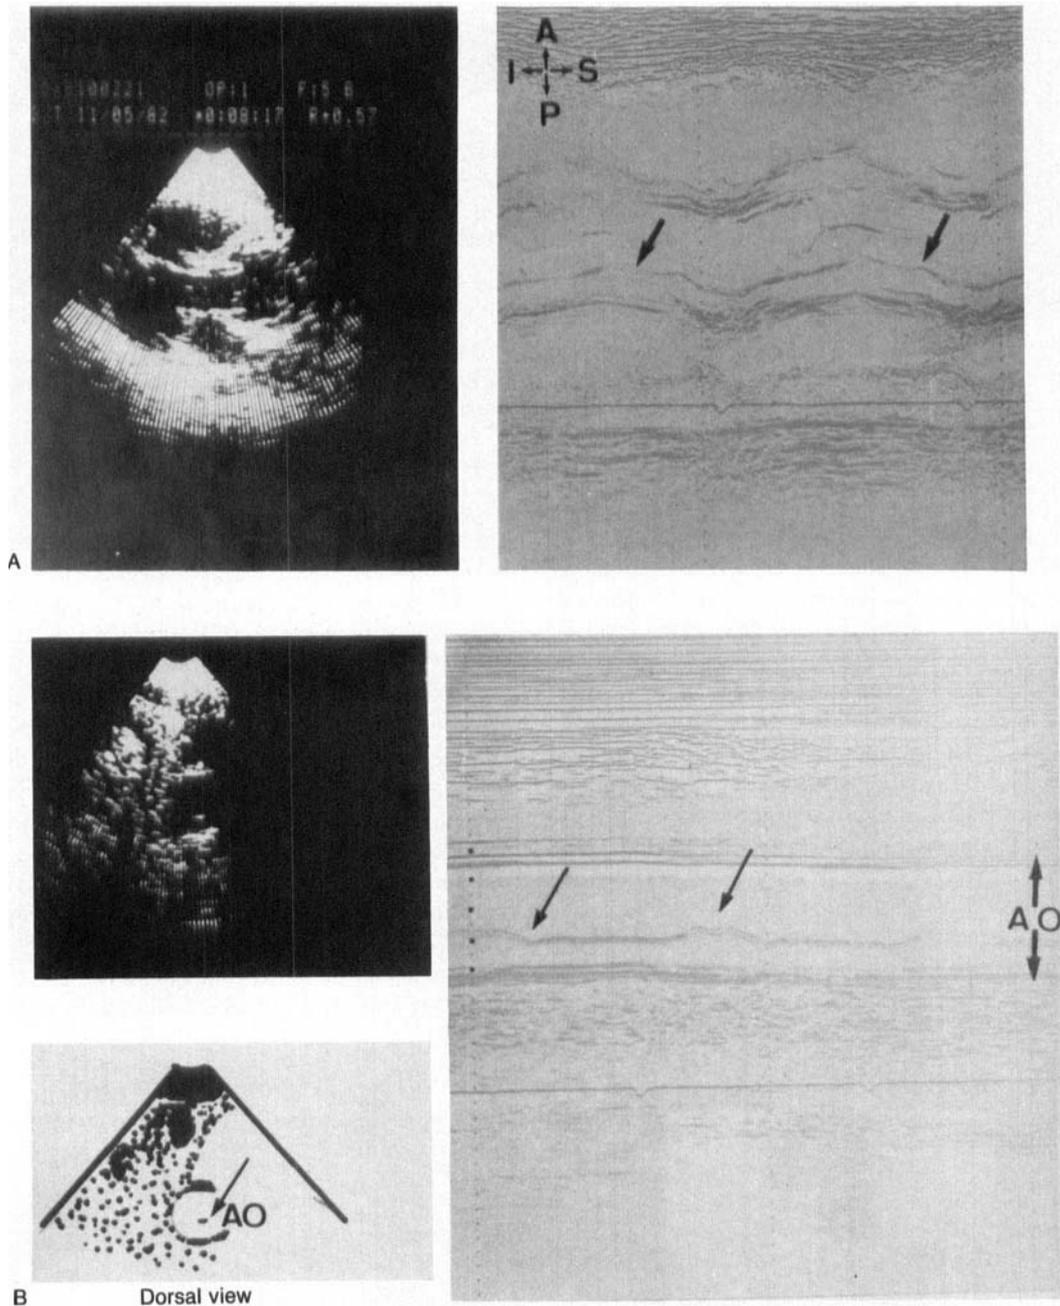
Example of a false positive echocardiographic diagnosis of type I aortic dissection in a case of type III aortic dissection. (A) Parasternal long-axis view at the level of a dilated ascending aorta, we can see a small abnormal echo which seems to duplicate the posterior aortic wall. (B) Dorsal view, a pulsating intimal flap is recorded at the level of the descending thoracic aorta. Ao: aorta, A: anterior, I: inferior, P: posterior, S: superior.
